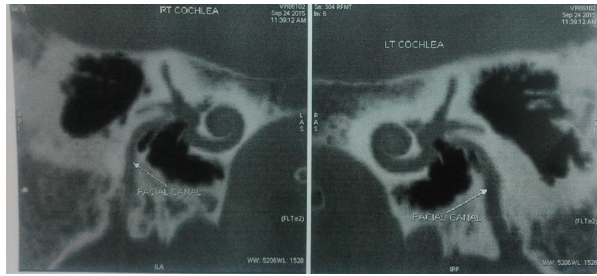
MRI of the left and right cochlea showing abnormal cochlear nerves with respect to the facial canal. MRI, magnetic resonance imaging.
